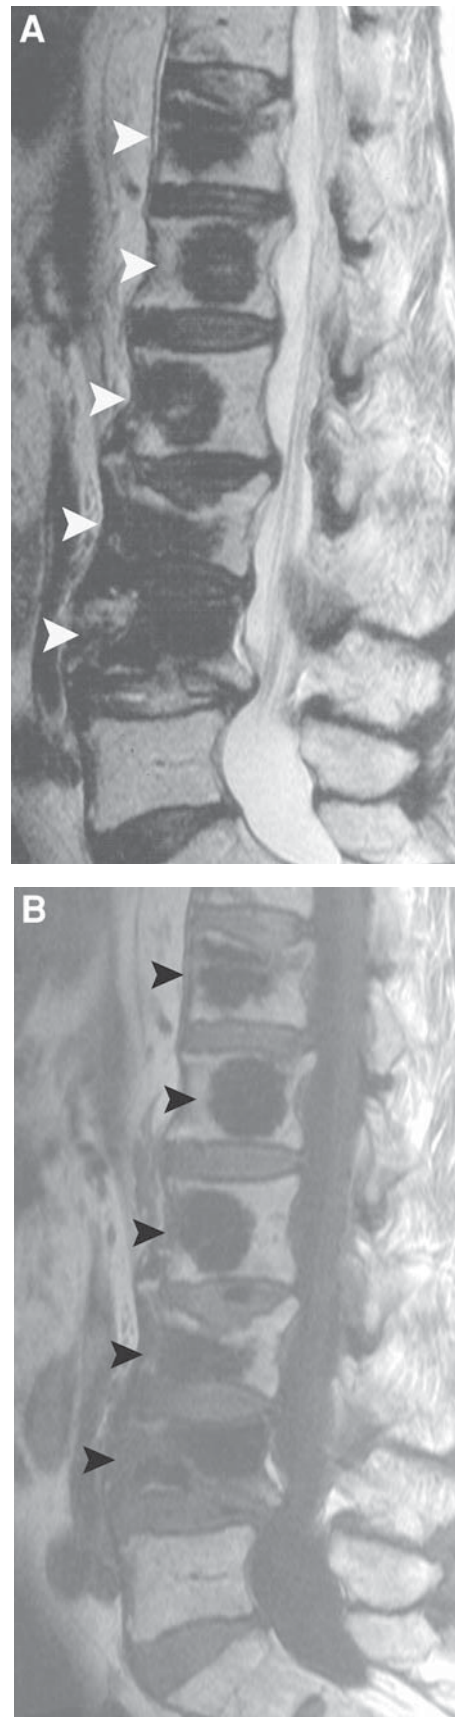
Vertebroplasty. Sagittal T2-weighted (A) and sagittal T1-weighted (B) images show the hypointense vertebral body signal seen after multiple vertebroplasty procedures in this patient with osteoporotic compression fractures.
